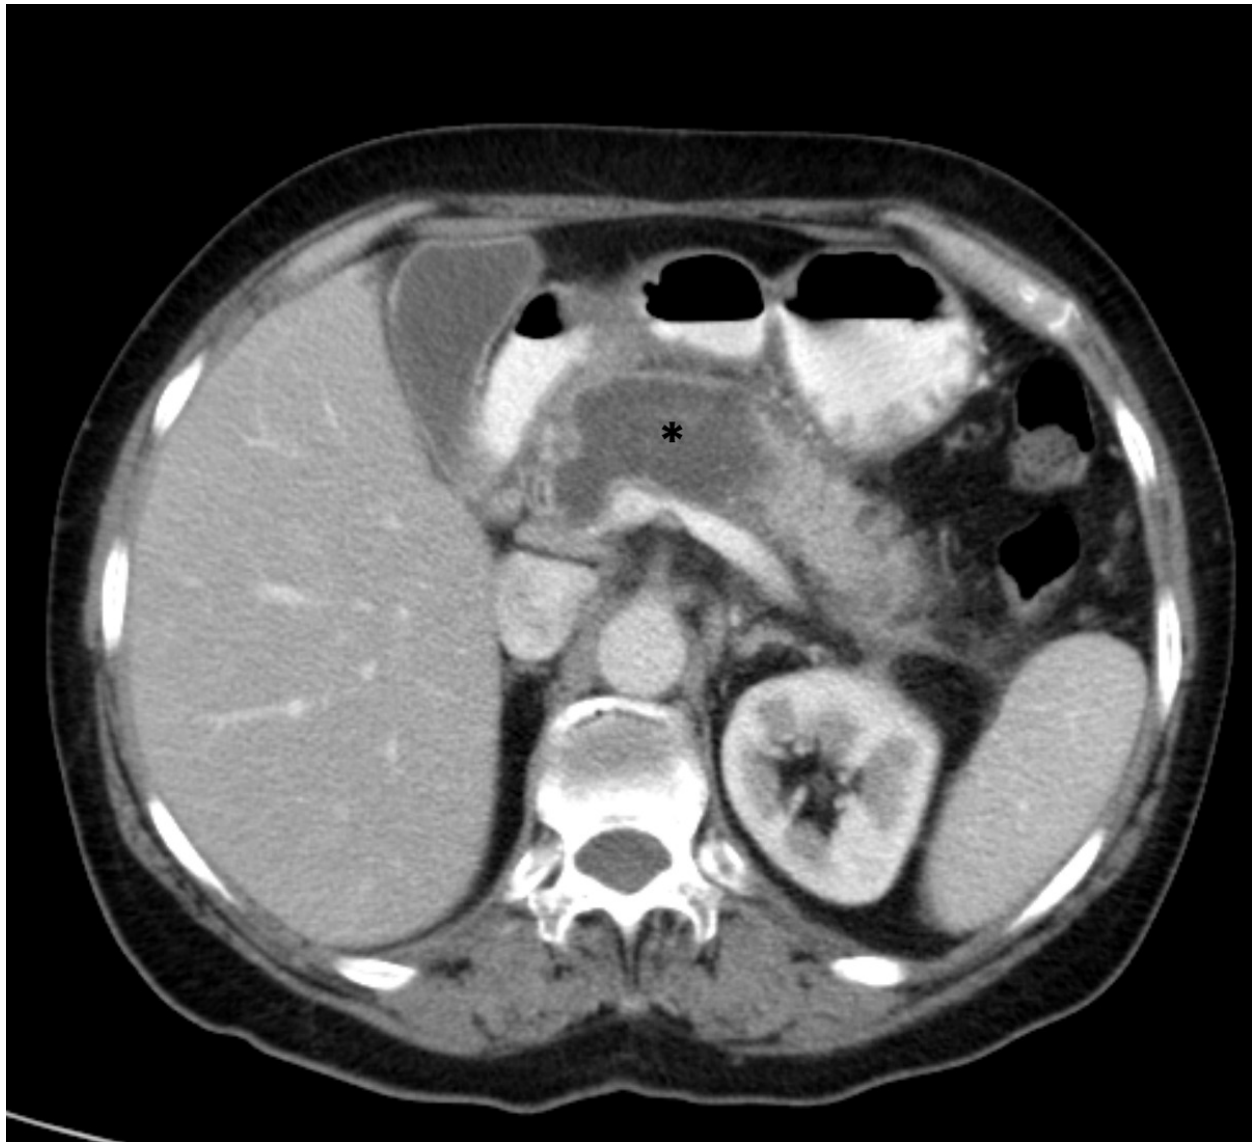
Contrast enhanced abdominal CT in the portal phase in an acute pancreatitis. The pancreatic parenchyma has a normal enhancement, with no hypoattenuating areas (asterisk); they are no signs of infection. This case should be classified as an interstitial edematous pancreatitis.
